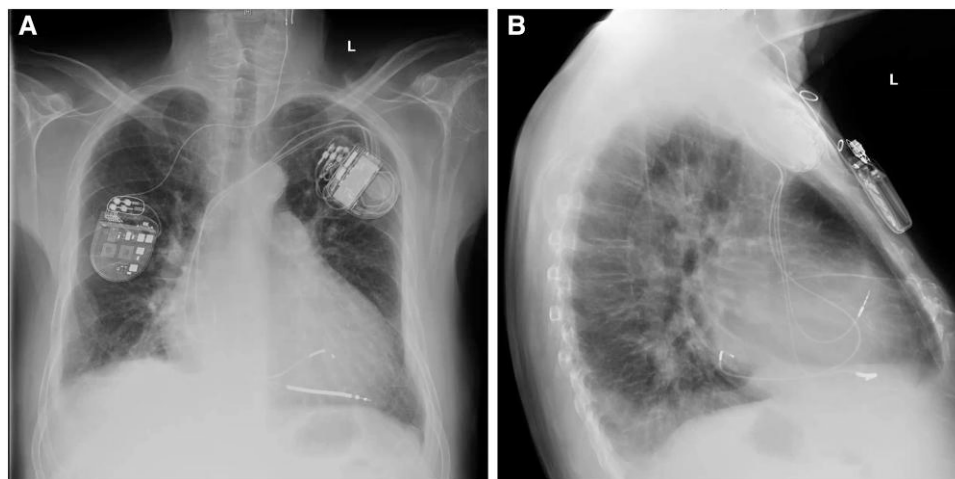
Chest X-ray from the front (A) and lateral (B) depicting the baroreflex activation therapy device (right chest) and the cardiac resynchronization therapy defibrillator (left chest) in the frontal recording (A).
